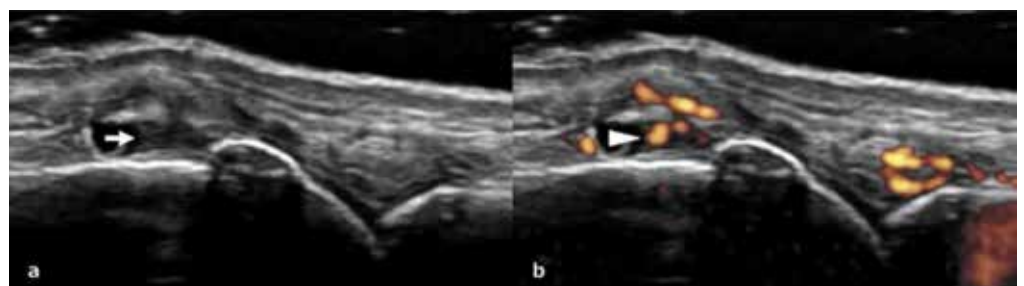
a Synovial hypertrophy (arrow) is observed in metacarpophalangeal joint. b Power Doppler signal in the synovial tissue (arrow head) indicates inflammatory synovitis. a, b Longitudinal scans.
